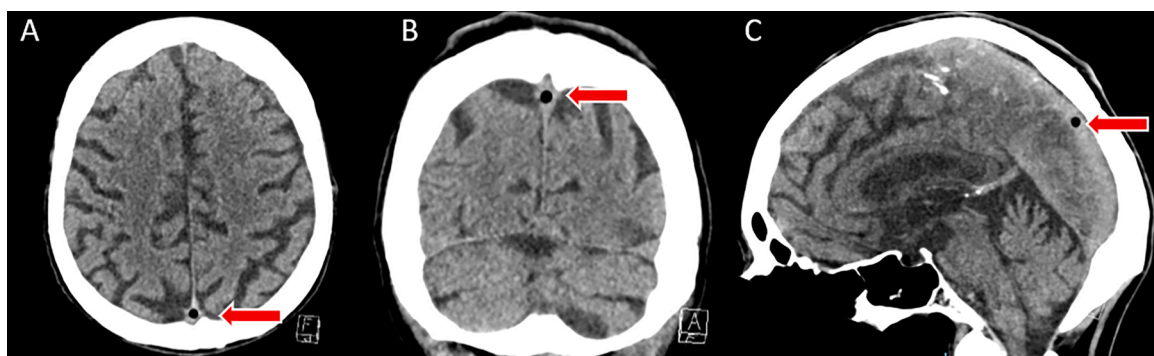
Non-contrast enhanced CT brain images with axial (a), coronal (b) and sagittal (c) views: Demonstrating a single air embolus in the superior sagittal sinus (red arrow).
